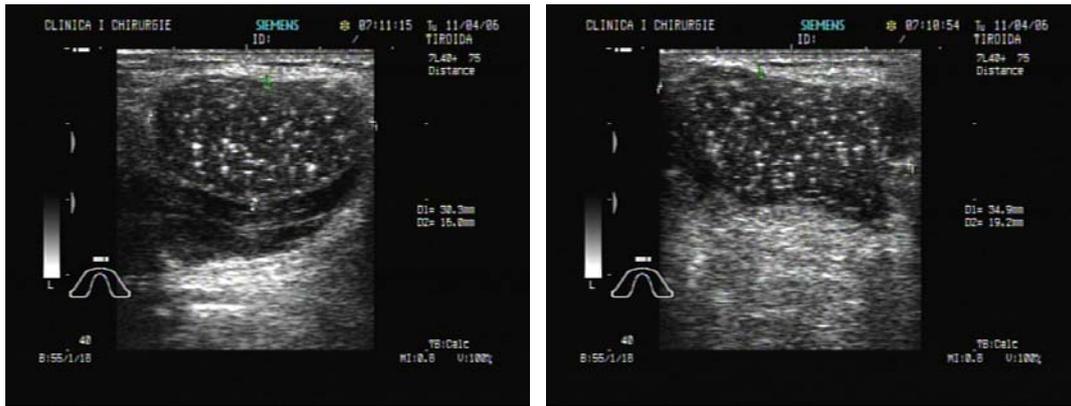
Ultrasound scan revealed a cystic mass, with a thick content
